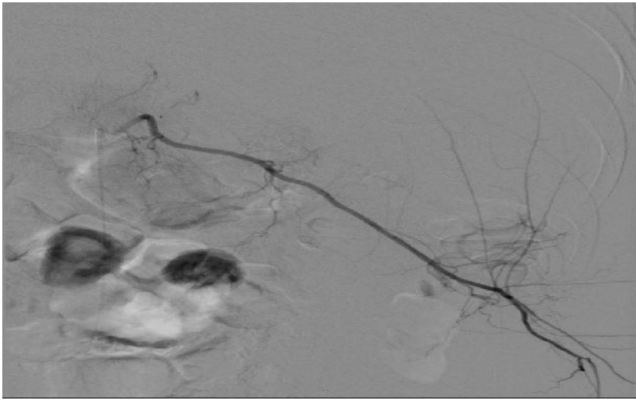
Computed tomographic (CT) angiogram displaying a splenic artery without any vascular malformation nor active bleeding.
